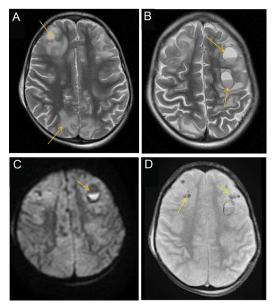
A: Axial T2 shows typical findings of PRES B: Axial T2 shows two lesions with fluid level (arrows) which are suspicious of abscess at first glance C: DWI shows the signal of the lesion to be high in dependent portion(arrow) which is suspicious but not typical for abscess as abscess shows more uniform increased signal. D: Axial T2 gradient shows multiple low signal foci (arrows) The overall findings are suggestive of hemorrhage rather than abscess.
